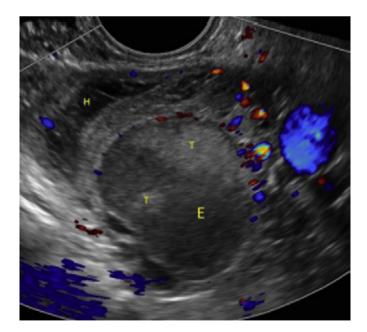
Color Doppler image of an ovarian endometrioma (E) with tumefactive debris (T). A hemorrhagic cyst is also present (H).⁶
